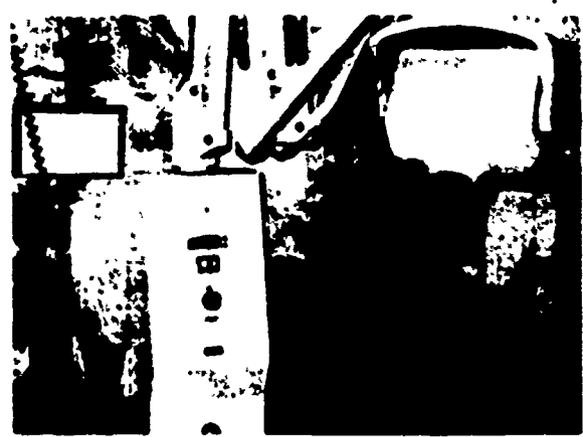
The dental X-ray unit.
